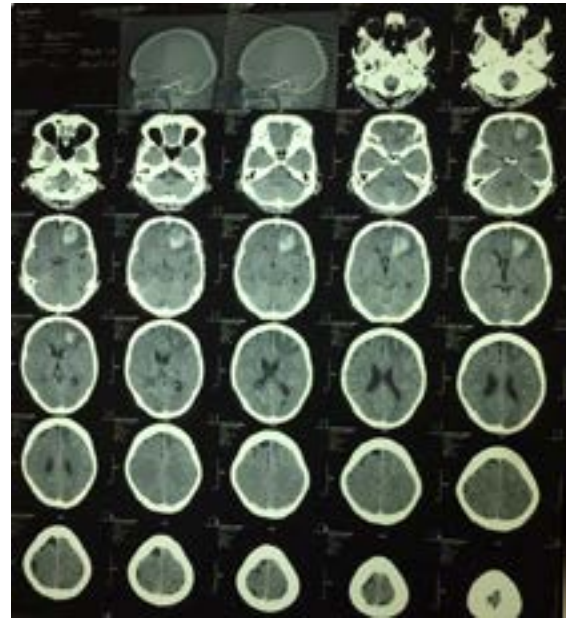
CT brain showed acute intraparenchymal bleed at the left frontal lobe
